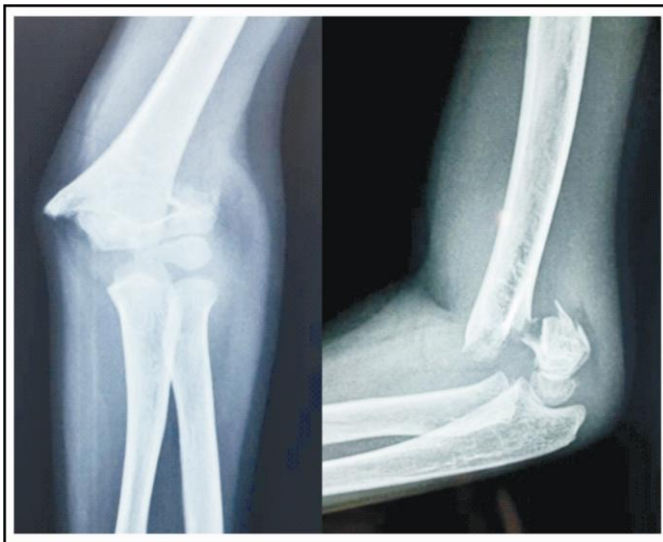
X-ray of elbow joint AP and Lat. Views showing Gartland type III supracondylar fracture.
